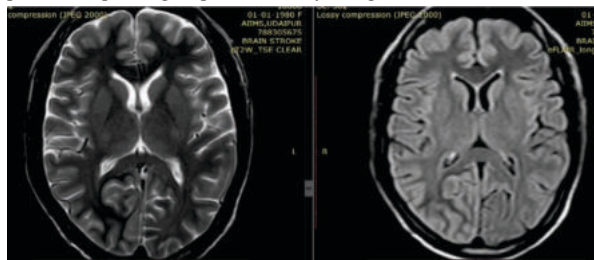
T2W SequenceFigure 4B:- FLAIR Sequence
